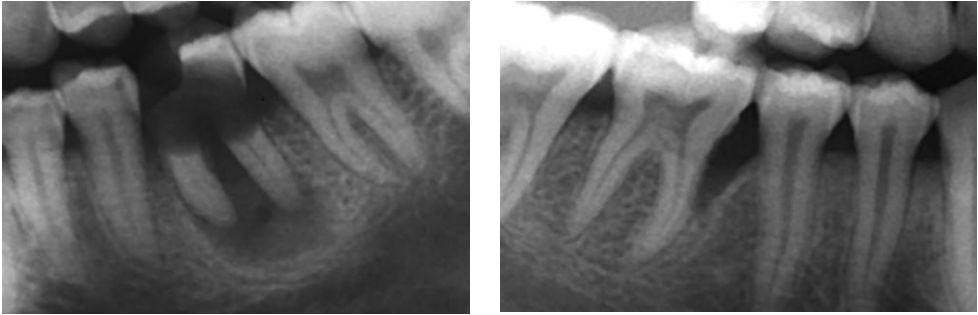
On left: Radiographic view of periapical lesion related to carious left lower first molar. On right: Deep periodontal pocket caused by periodontitis in lower right first molar (adapted from Article II).
